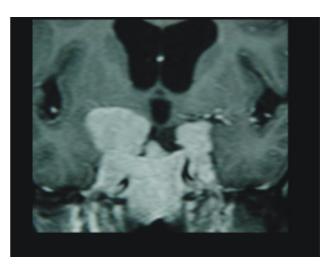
Coronal MR image demonstrates a Grade III giant pituitary adenoma with bilateral cavernous sinus invasion. The tumor elevates roofs of both cavernous sinuses and diaphragma sella. B. T2-weighted coronal image shows the trifoliate tumor.
